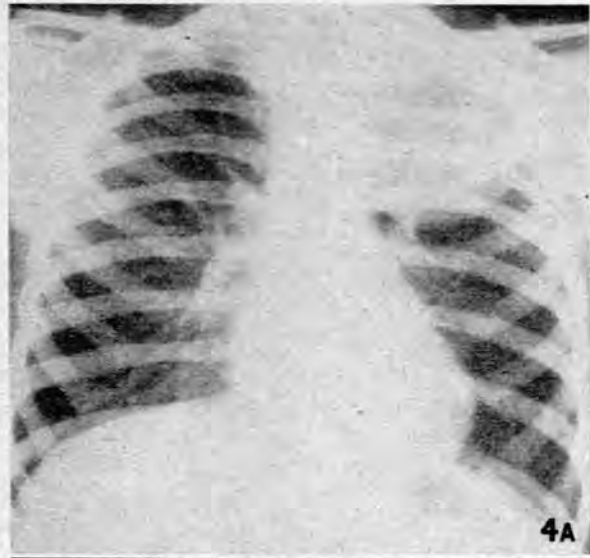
The AP (A) and left lateral (B) radiographs in a boy of 6 years with a duplication of oesophageal origin.
